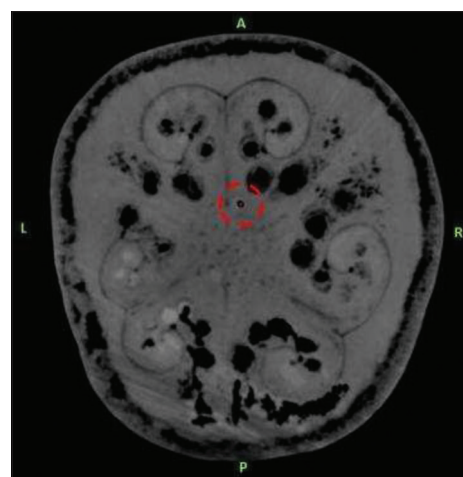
The second deepest computed tomography slice on which that deep brain stimulation electrode was clearly visible is shown in Figure 4. The red dot which is highlighted with dashed circle is the target point for all 3 scenarios.
